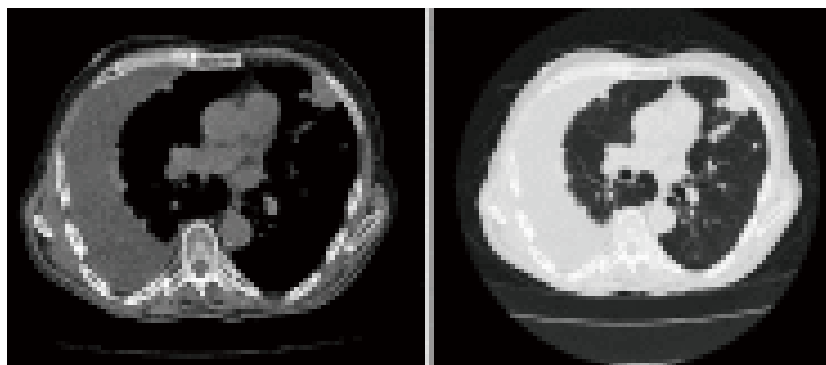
CT scan of the chest showing large right-sided pleural effusion with pleural and parenchymal nodularity. CT, computed tomography [11]
